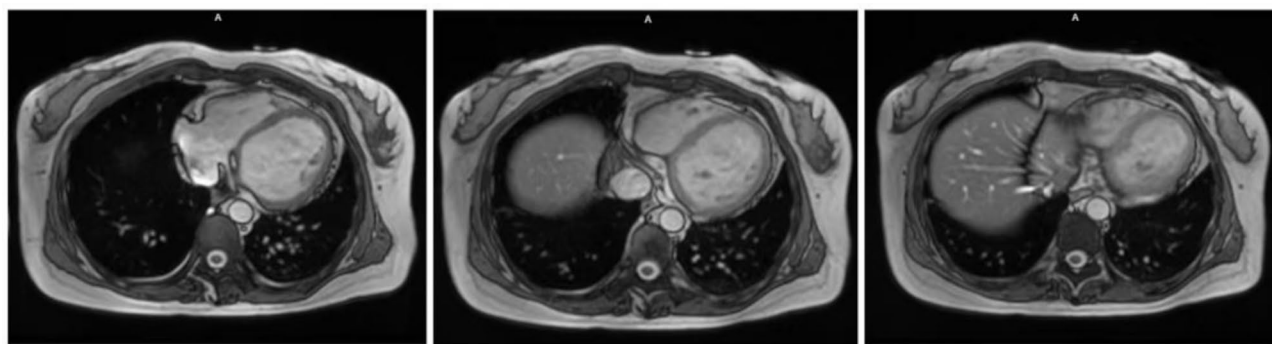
Cardiac MRI images exhibited an enlarged heart mainly with the right atrium and left ventricle enlargement, a few punctate and linear low-signal perfusion defect areas can be seen in the basal part of the ventricular septum and part of the free wall myocardium of the left ventricle, and there is a small amount of pericardial effusion
